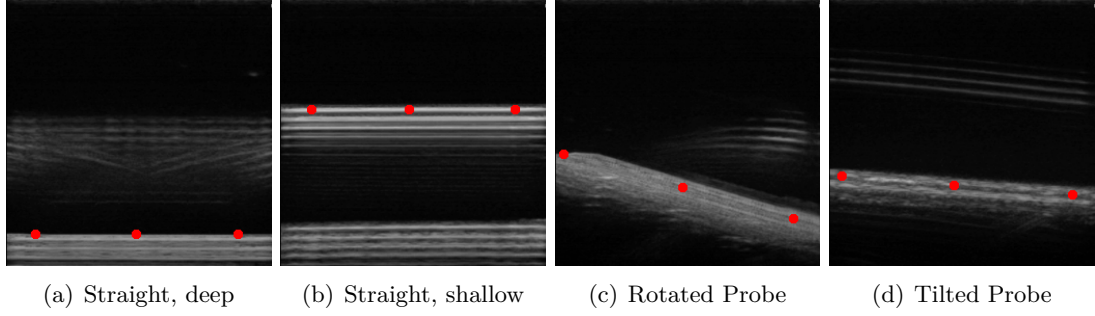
Ultrasound images from the water bath calibration scan, red dots show points used for the floor reconstruction.
